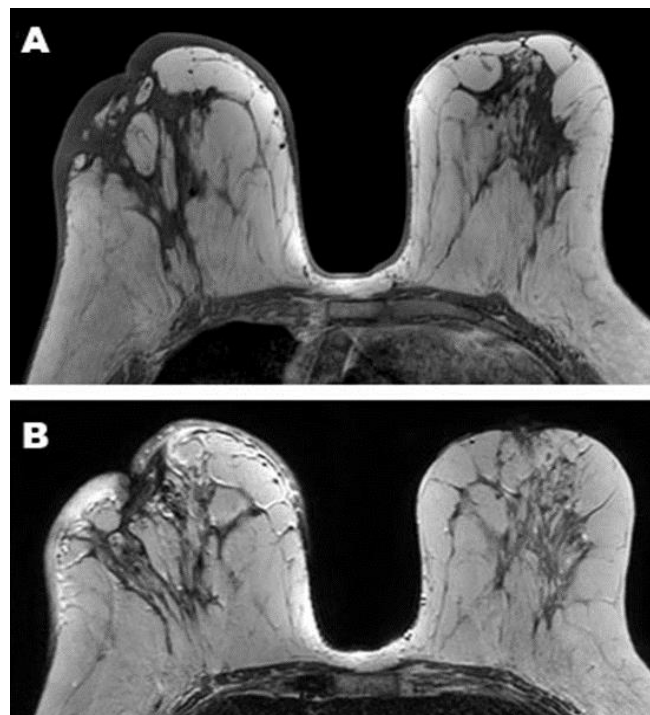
An example of breast MRI modalities: (A) T1, (B) T2
